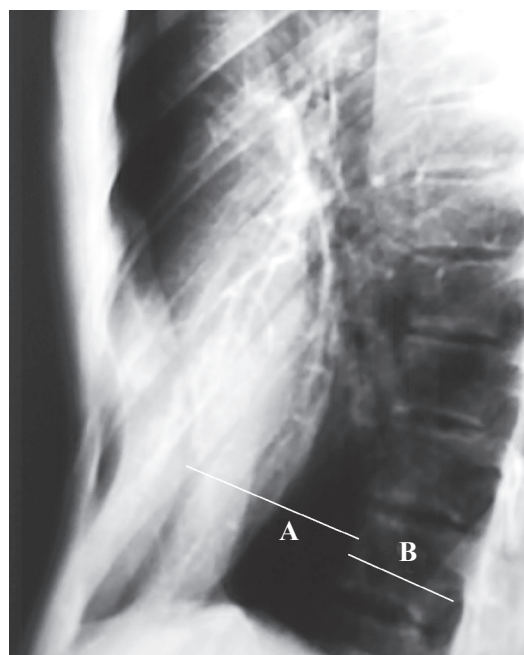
Lateral projection radiograph
